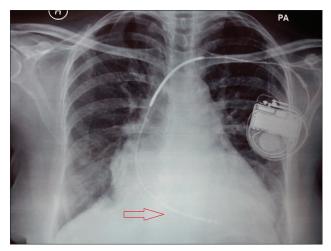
Preoperative chest X-ray showing the automatic implantable cardioverter defibrillator *in situ*. Thick radiopaque shock coil seen in the right ventricle
